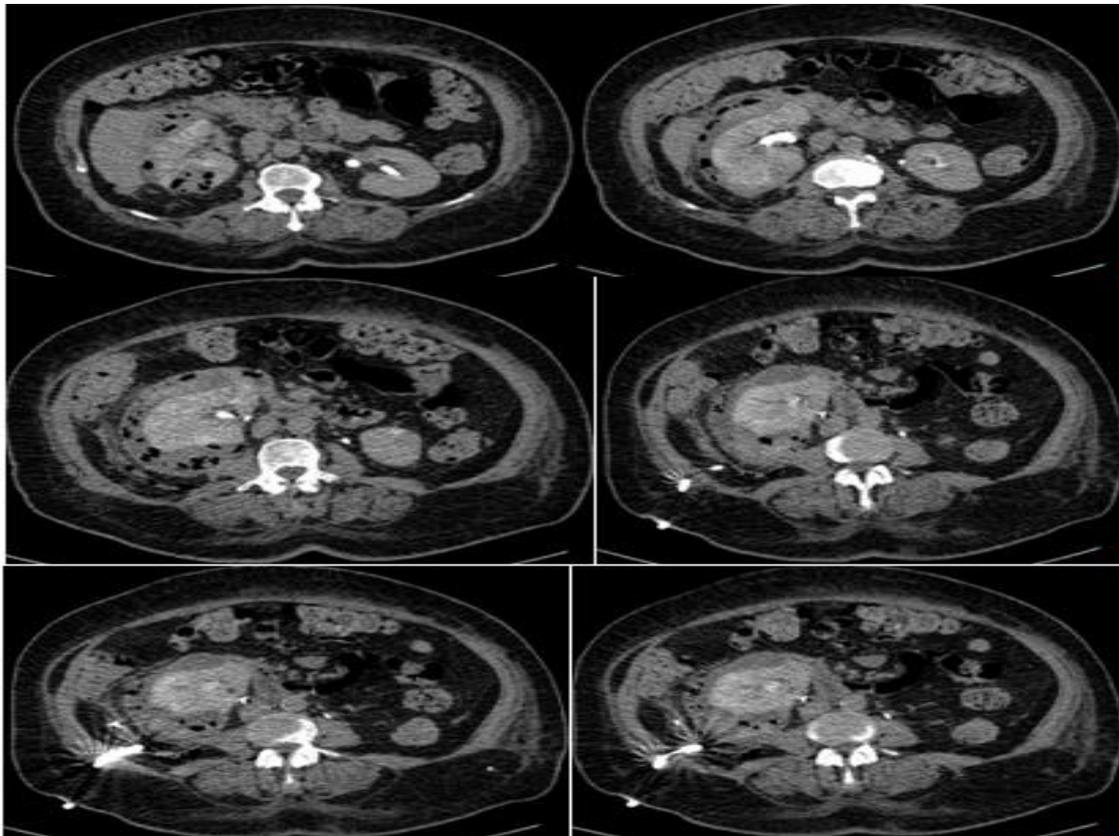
abdominopelvic* CT scan with contrast medium: a nucleus of gas bubbles, communicating with a subcapsular collection and gas bubbles, a similar *arch-like* collection at the level of the right perirenal fascia.
